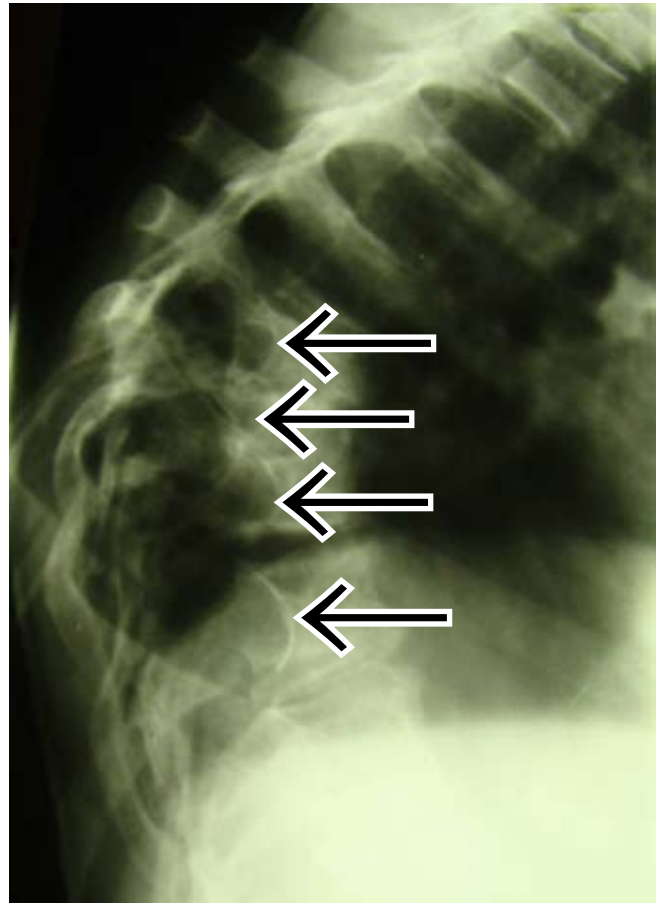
Lateral X-ray of the thoracic spine showing enlargement of the neural foramina at multiple levels and posterior vertebral scalloping gibbus owing to multiple dumbbell tumours and dural ectasia.
